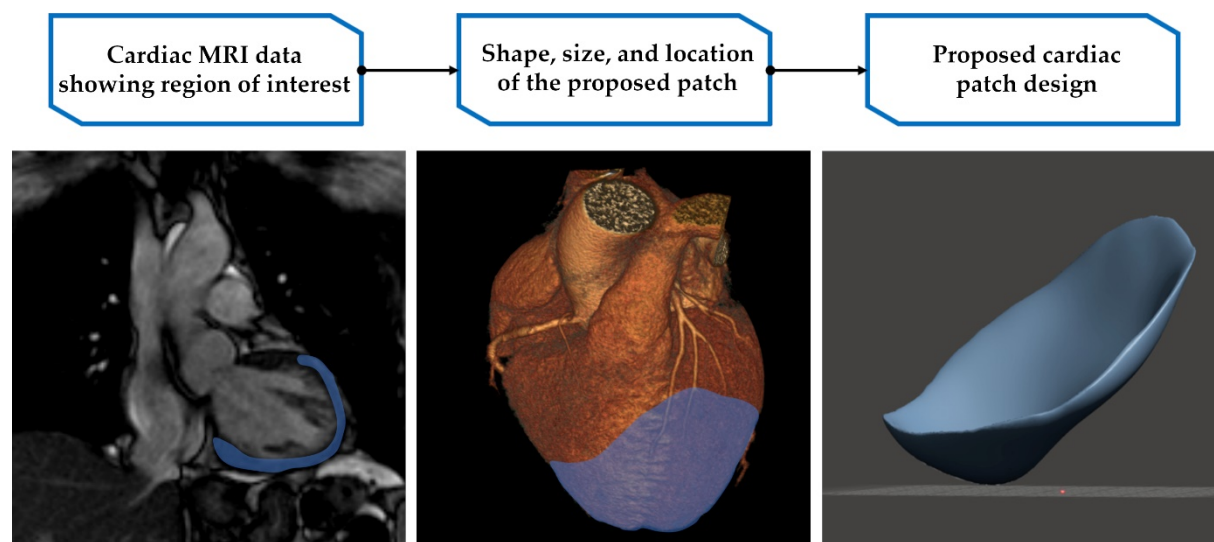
3D design of personalised cardiac patches using MRI and CT scan data. The infarcted region in the myocardium is identified in a cardiac MRI, and a cardiac CT scan captures the anatomy of the LV wall. Data from the scans is used to create a digital 3D model of a patient-specific cardiac patch. (Source: Matthews et al. 2022)¹
